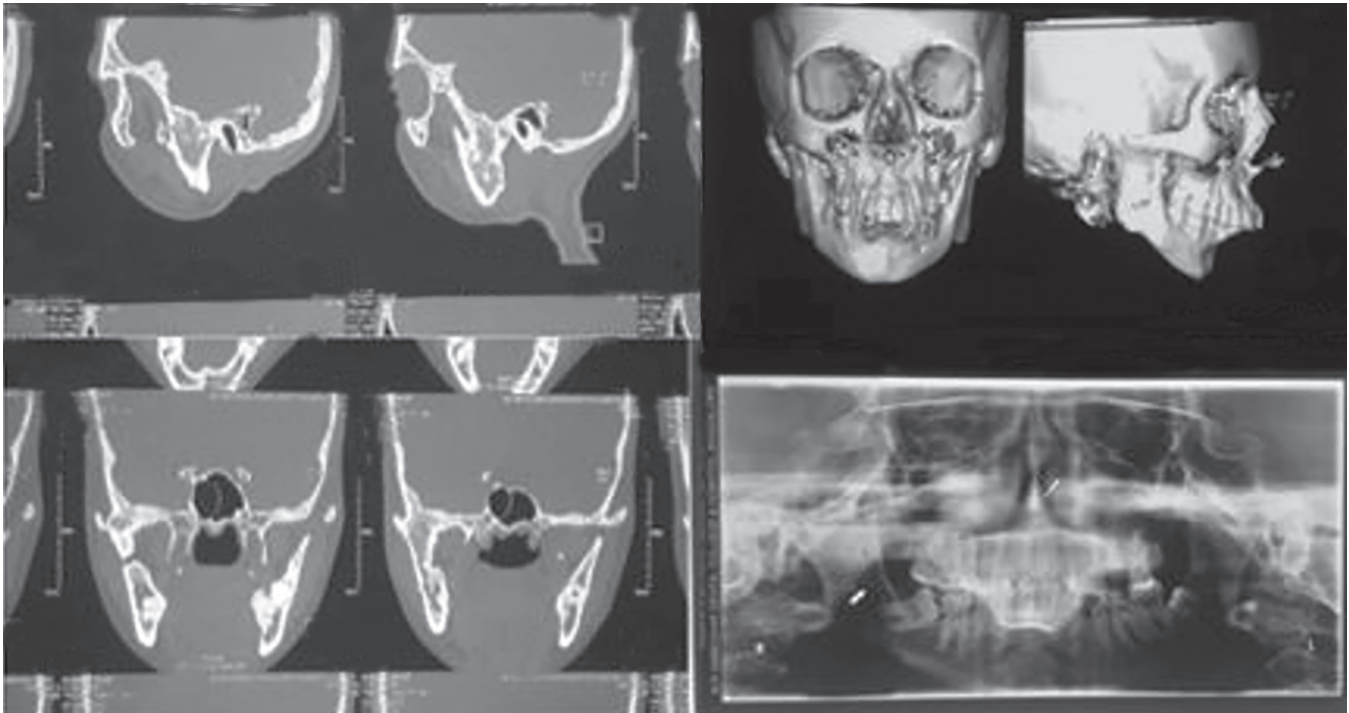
Preoperative images: Clockwise from R-L: CT sagittal section, 3D reconstruction images, OPG, CT coronal section
